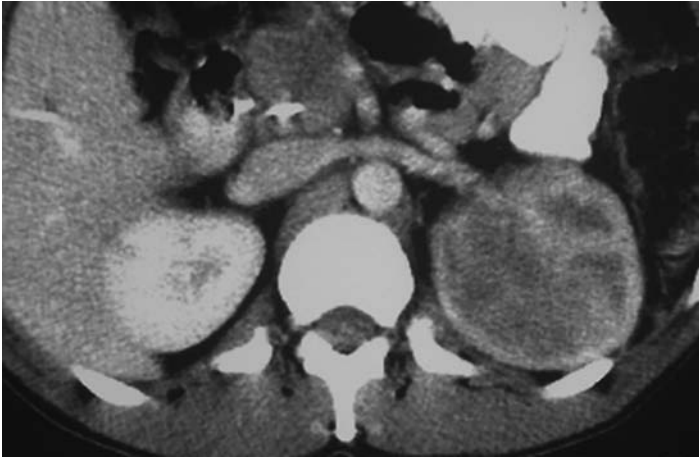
Contrast-enhanced CT showing a large solitary mass occupying and expanding the upper pole of left kidney. The mass is poorly enhancing and ill-defined. The expanded kidney retains its normal reniform contour.
